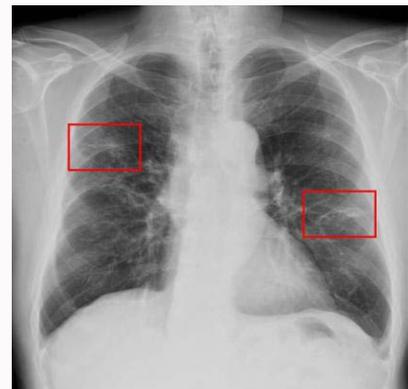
Chest X-ray after pazopanib stopping and steroid treatment: resolution of previous lung abnormalities with two residual areas of septal thickening.
